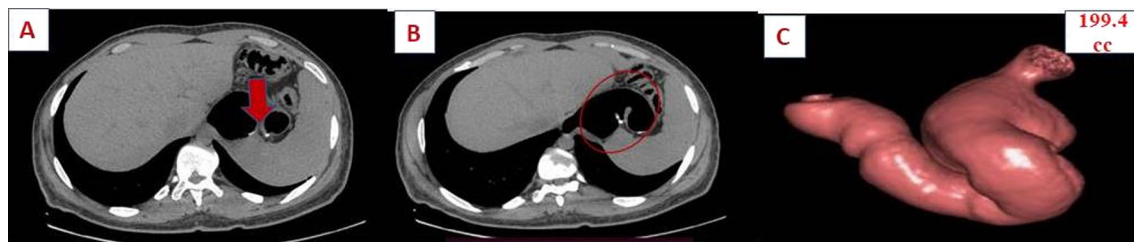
A 29-year-old obese male (BMI = 46) with postoperative gastric volume is 199.4 cc. Preoperative weight and 1-year postoperative weight were 133 kg and 83 kg, respectively. Weight reduction percentage is 37.6%, and 1-year postoperative BMI is 28.7. % of loss from the excess weight = 79.3%. Although the postoperative gastric volume is high, the patient weight loss after 1 year is high. A, B CT abdomen are showing staples (arrow) and gastric pouch (circle). C 3D CT gastric volumetry showing gastric volume of 199.4 cc
